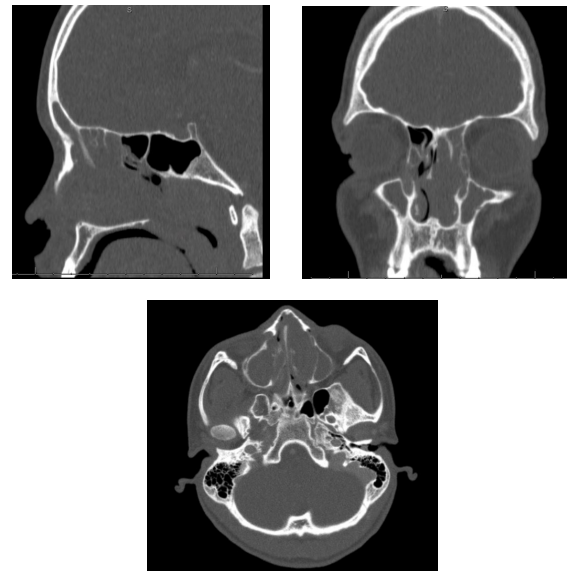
Preoperative CT Imaging
